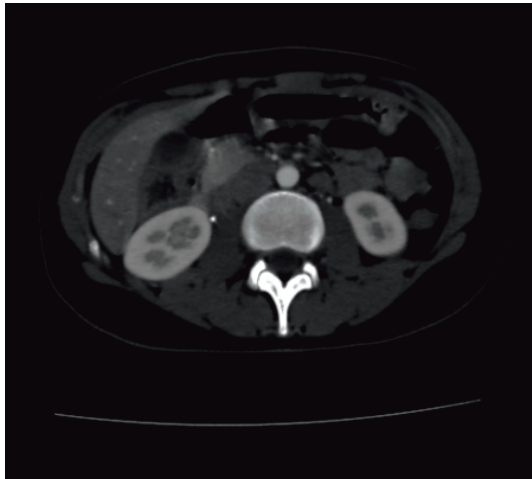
Abdominal CT shows a distended stomach with an air-fluid level and dilated the first part of the duodenum without an apparent transition
